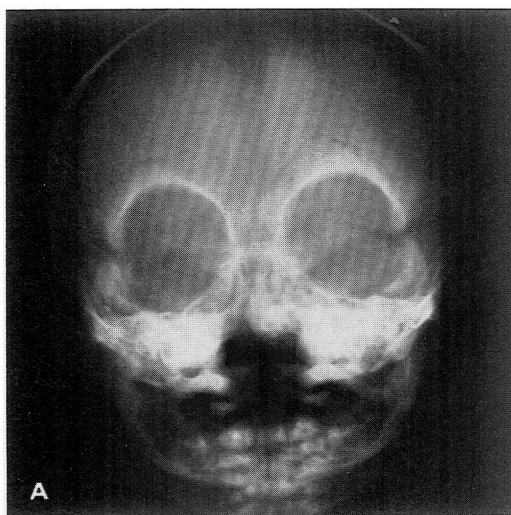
Patient 1. Frontal roentgenogram indicates orbital hypotelorism with hypoplasia of nasal and median facial bones. Longest diameters of the orbits are vertically oriented and contour of superior margins is semicircular ("half moon"). Note wide distance between palatal shelves and presence of Microcephaly.
